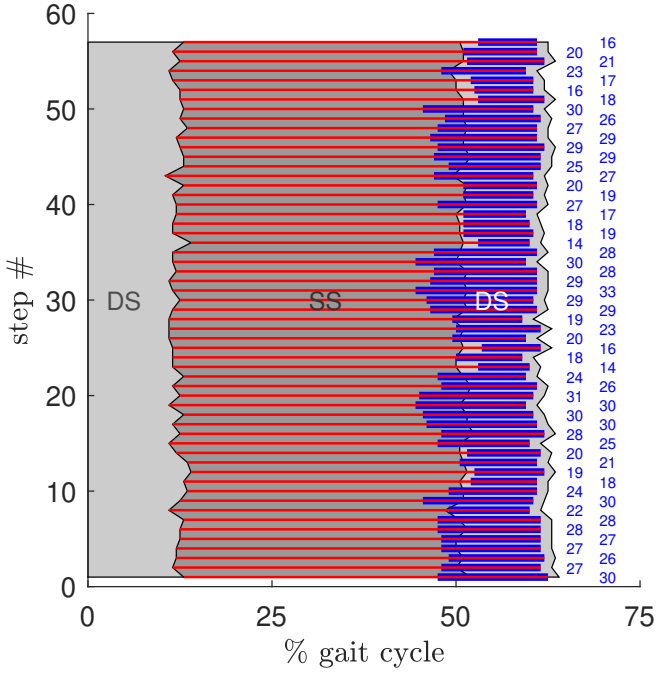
STEP TIMING FOR ALL (57) RECORDED STEPS OF A SINGLE SUBJECT. THE SINGLE SUPPORT PHASE (SS) IS PRECEDED AND FOLLOWED BY DOUBLE SUPPORT PHASES (DS), INDICATED BY THE GRAY SHADED AREAS, IN EARLY AND LATE STANCE. BLUE BARS INDICATE THE PERIOD FOR WHICH EXPERIMENTAL DATA OF THIS STEP HAVE BEEN USED TO DETERMINE THE OPTIMIZED CoR POSITION IN THIS SPECIFIC STEP; THE NUMBER OF SAMPLES ARE NOTED RIGHT TO THE RESPECTIVE BAR. THE RED BAR INDICATES THE PERIOD FOR WHICH THE RESIDUAL OF MEASURED VERSUS OPTIMISED LEVER LENGTH HAS BEEN CALCULATED.
